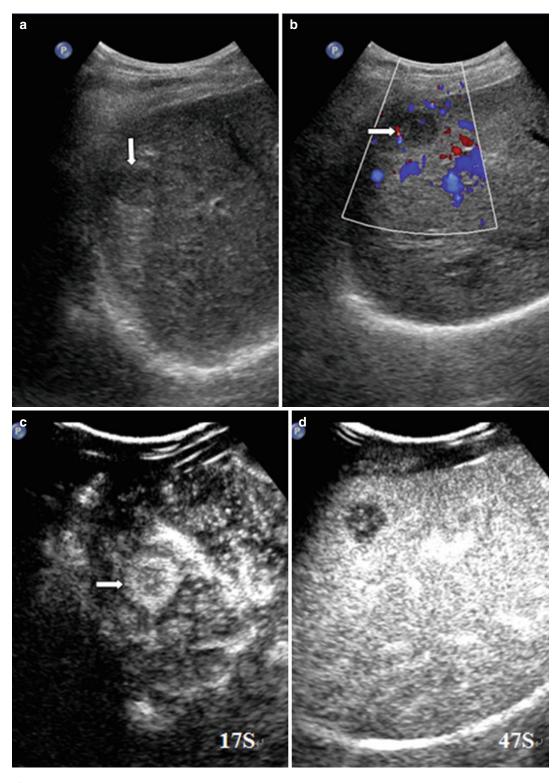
(a) Hypoechoic hepatic lesion (*arrow*). (b) Color Doppler ultrasound showing linear color blood flow in surrounding area of the lesion (*arrow*). (c) Contrastenhanced ultrasound showing arterial phase of liver lesion
